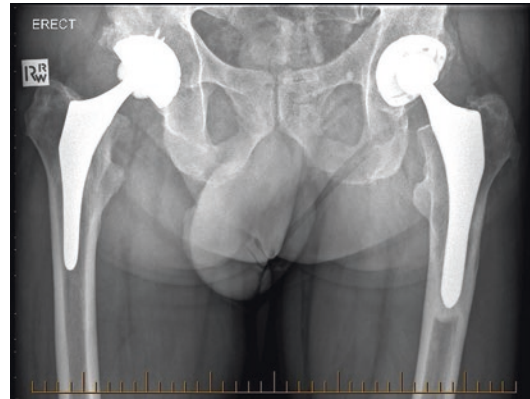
Anteroposterior radiographs of the right hip demonstrating ceramic-on-ceramic articulation and abduction angle of 51°
